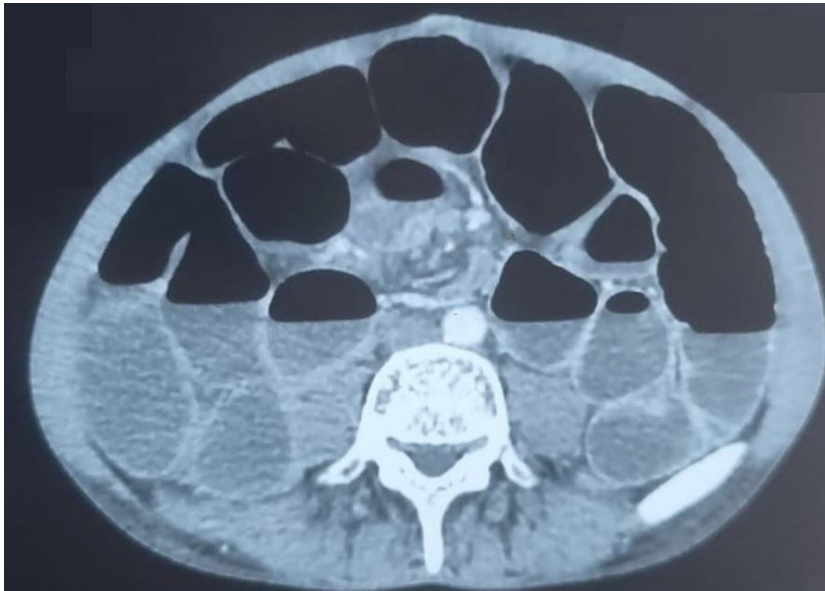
and Figure 2 : CT scan of the abdomen showing the twisting of the ileum around its mesentery (whirl sign).
